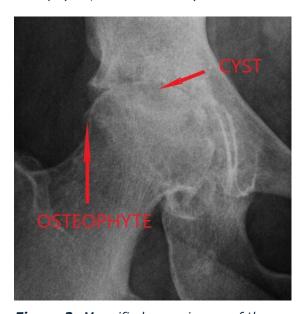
Magnified x-ray image of the right hip showing osteophytes, cysts and complete joint space obliteration with bone-on-bone contact
